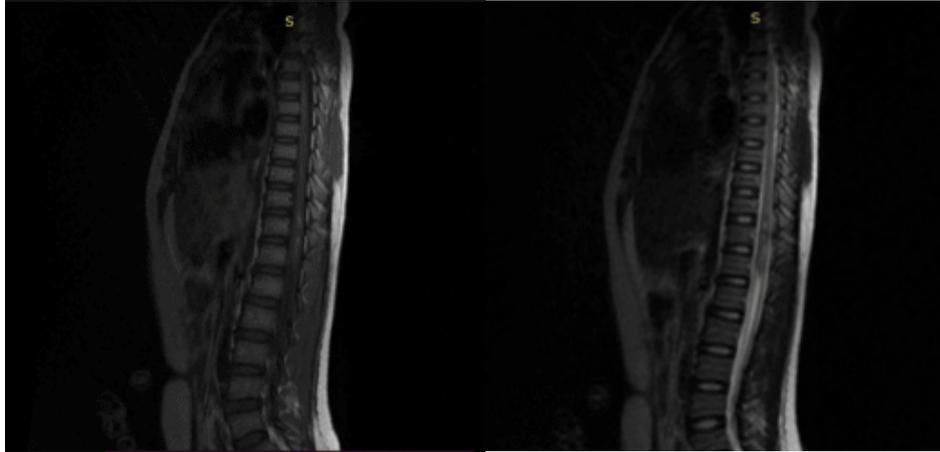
Sagittal T1FSE & T2frFSFs with contrast Thoracolumbar MRI
